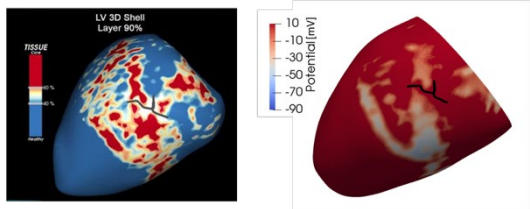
LGE-MRI of the patient's scar with the slow conduction channel (left panel) and the numerical model (right panel)
